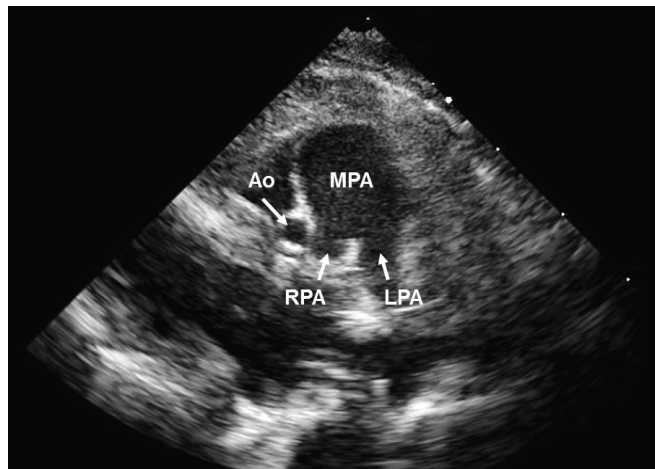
Transthoracic echocardiogram displaying the diminutive ascending aorta.
